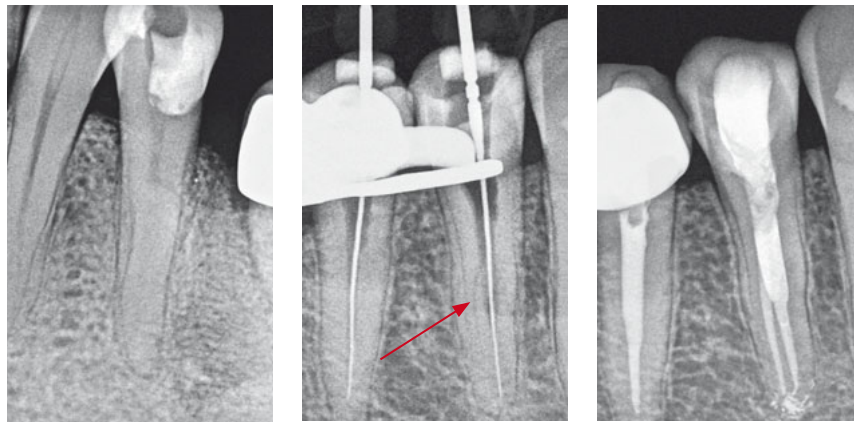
The eccentric working length radiograph reveals a branched canal (arrow).
